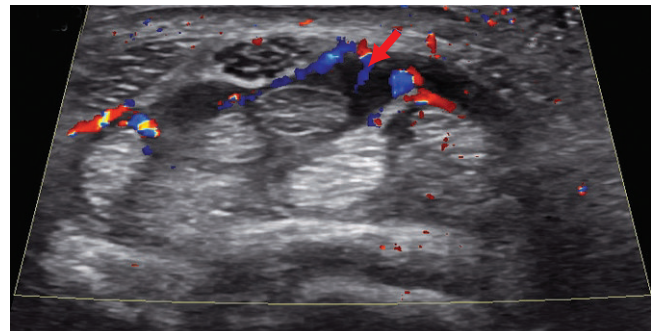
The transverse image of extensor compartment four on the dorsum of the wrist shows increased color Doppler flow of the thickened synovium (arrow) indicating tenosynovitis.
